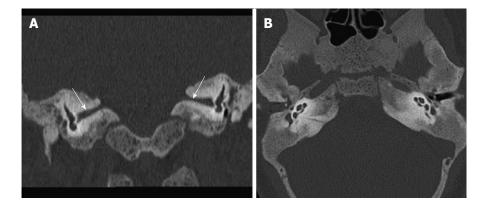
Coronal reformatted high resolution computed tomography. (A) image showing thickened sclerotic bones causing narrowing of bilateral internal auditory canal (arrows); normal cochlea and vestibule seen in both ears on axial high resolution computed tomography image (B).
